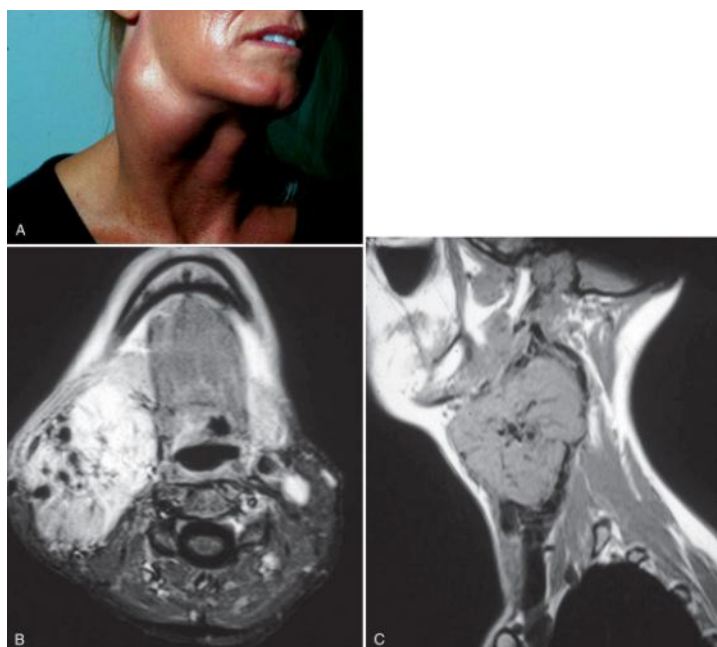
A, Patient with a mass in the neck, which has increased in size over a 10-year period. B, Magnetic resonance imaging demonstrates a large carotid body tumor with numerous flow voids. C, Lateral view of mass extending to prevertebral fascia.
